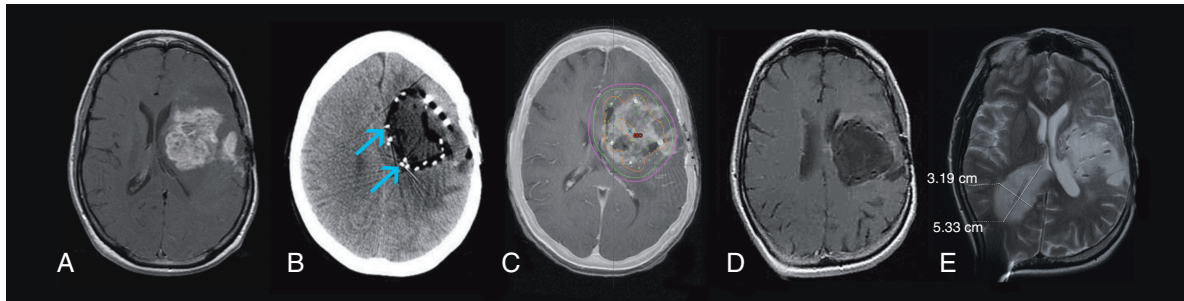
Case 102, left parietal tumor. (A) preoperative axial contrast enhanced T1, postoperative day 1 imaging with (B) CT (with sources at arrows) and (C) contrast enhanced T1 axial MRI with radiation isodose lines (Magenta 60 Gy, Green 80 Gy, Orange 100 Gy). Follow-up MRI imaging shown is (D) 6-month contrast enhanced T1 axial, and (E) 11-month axial T2 with recurrent contralateral tumor.
